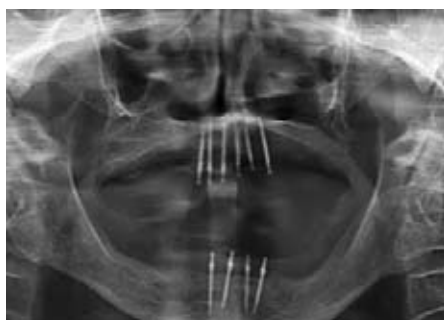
Radiograph of implants in situ
